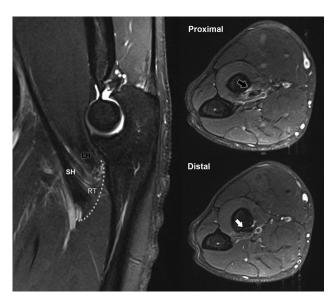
Representative sagittal (left) and axial (right) T2 fatsaturated magnetic resonance imaging sequences demonstrating a partial long head (LH) (black arrow) tear at its insertion on the radial tuberosity (RT) and an intact short head (SH) insertion (white arrow).
